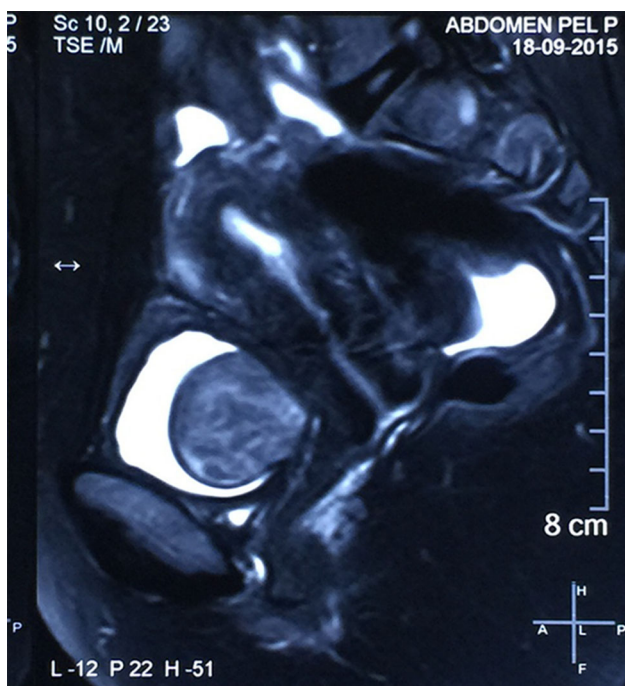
MRI of the patient showing bladder mass along posterolateral wall
